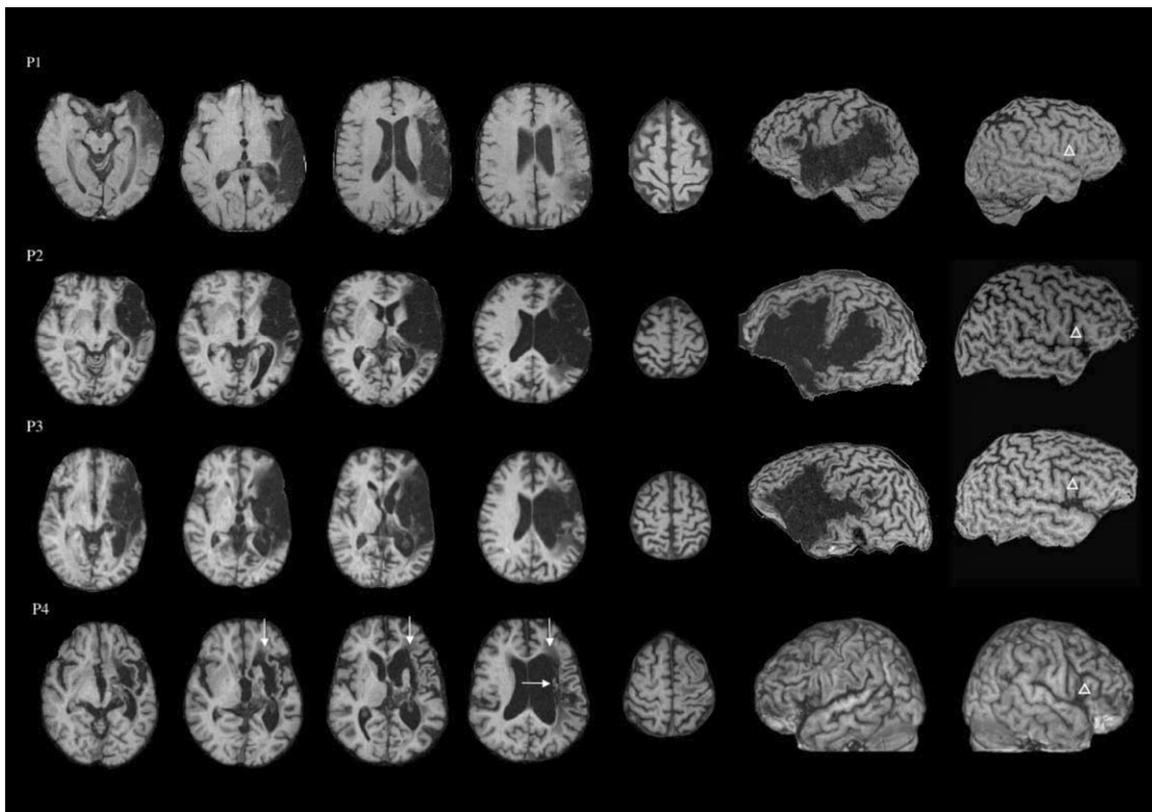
T1-weighted structural MRI scans for each chronic aphasia patient, 5–11 years poststroke, showing L hemisphere lesion. The L and R lateral views are reconstructed from a 3D MPRAGE MRI scan. The white triangle in R Broca's homologue marks the area of cortex that was suppressed with 1 Hz rTMS during each 20-min treatment session. This area was immediately rostral to the vertical (ascending) ramus of the Sylvian fissure. Patients P1–P3 had some lesion in L Broca's cortical area (pars triangularis and pars opercularis), however, the most severe patient, P4, with subcortical lesion only, did not. She had extensive lesion present in the two white matter areas near ventricle, compatible with severe nonfluent speech: (1) the medial subcallosal fasciculus, deep to Broca's area adjacent to the L frontal horn (vertical arrows); plus (2) the periventricular white matter, located deep to sensorimotor cortex, adjacent to the L body of lateral ventricle (horizontal arrow). See text for pathways in these areas. The mild and moderate nonfluent patients (P2 and P3) also had some lesion in these two, deep white matter areas. The recovered Broca's aphasia patient, P1, had almost no lesion in these two areas.
